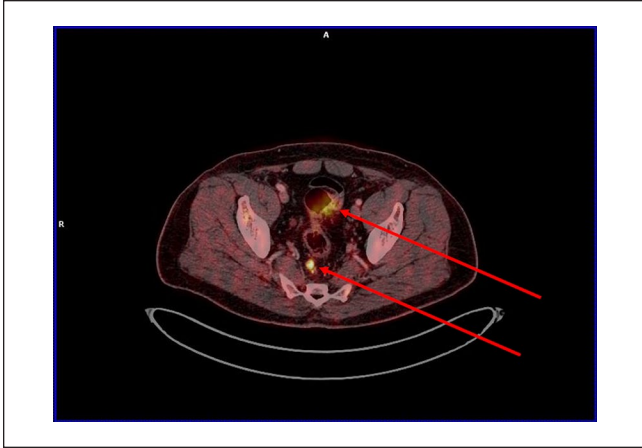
FDG-PET showing increased uptake at site of rectal tumor (top arrow) and presacral lymph node (bottom arrow). While FDG-PET did not pick up any activity in the prostate, it cannot be ruled out that a possible reason for lack of uptake was due to washout from a more intense signal from the rectal lesion as shown in the top arrow.
